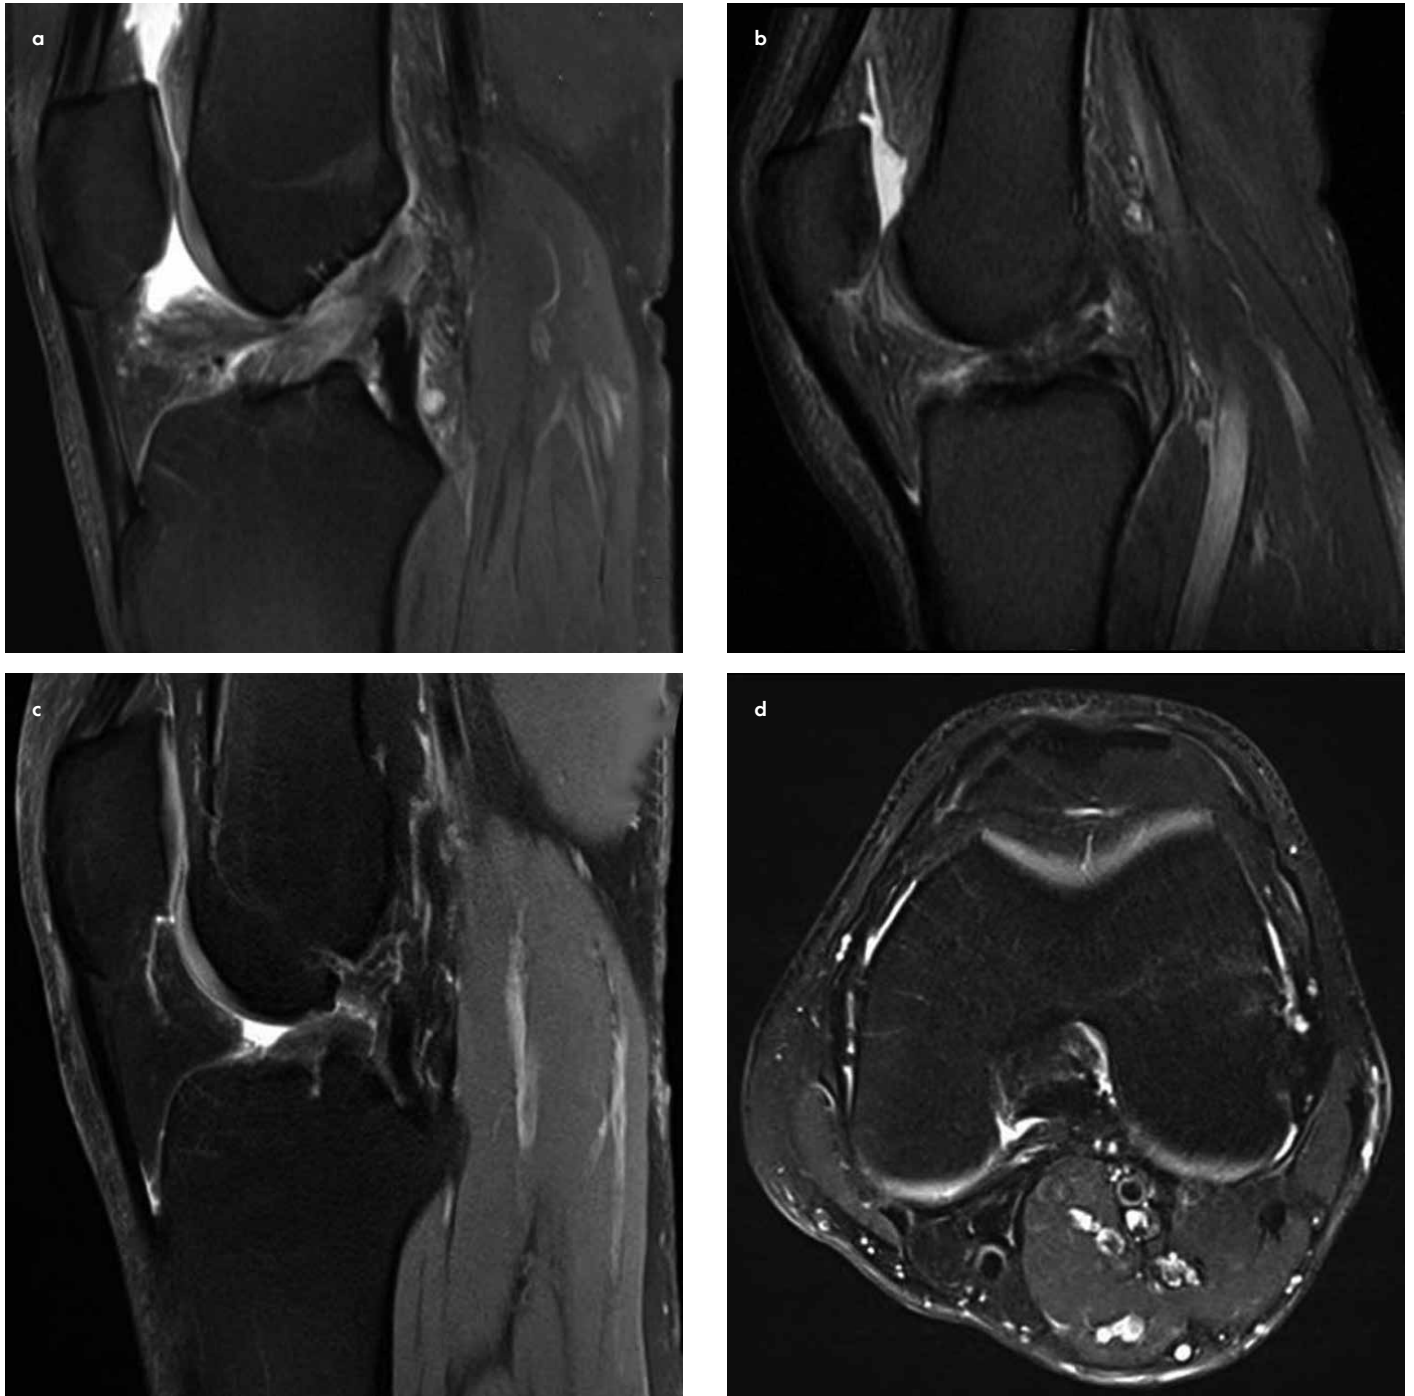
a-d. Three separate sagittal proton-density MRI images of the knees depict the anterior cruciate ligament disruption. Acute injury (a) subacute injury (b) chronic injury (c). Axial proton-density MRI images of the knee depicting a chronic anterior cruciate ligament disruption and "empty notch sign" (d).
